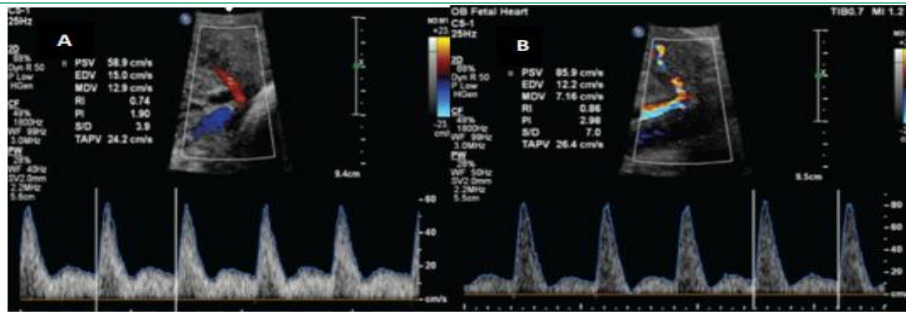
Abnormal second trimester uterine artery Doppler waveforms on the right (A) and left (B) sides characterized by a mean PI of 2.44 and bilateral diastolic notches (Quoted from Oloyede et al., 2013)
